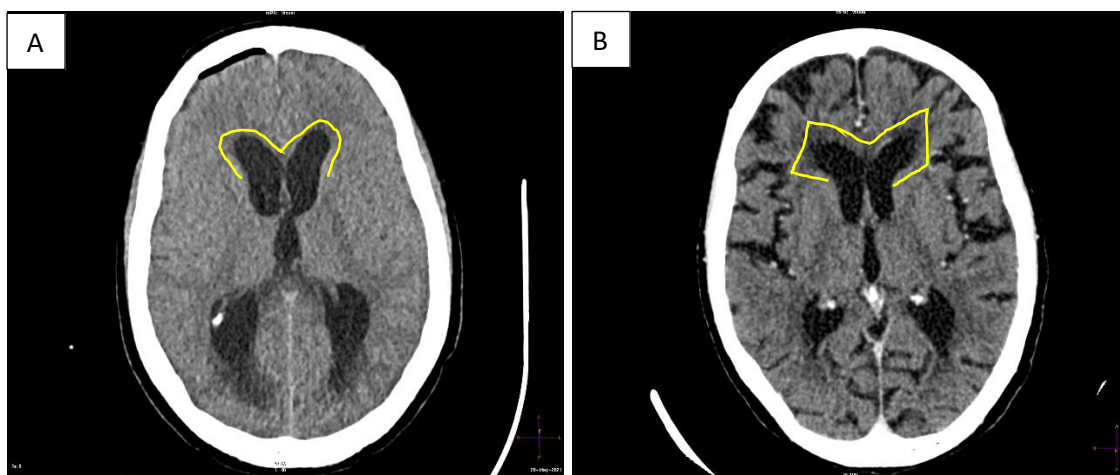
CT scans showing the A) round and B) quadrilateral frontal horn shapes.
